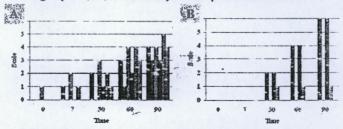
Conventional radiographic scale evaluation of HA-TCP and HA-C graft before and 7 until 90 days after implantation. A. Radiograph evaluation of HA-TCP. B. Radiograph evaluation of HA-C. implant opacity (II), bone opacity (III), internal implant radiolucent image (III), peripheral radiolucent of the implant (III), margination (IIII), degradation size of implant (III). Scale 1 is describe the lowest level of bone transformation, scale 6 is the highest level.
